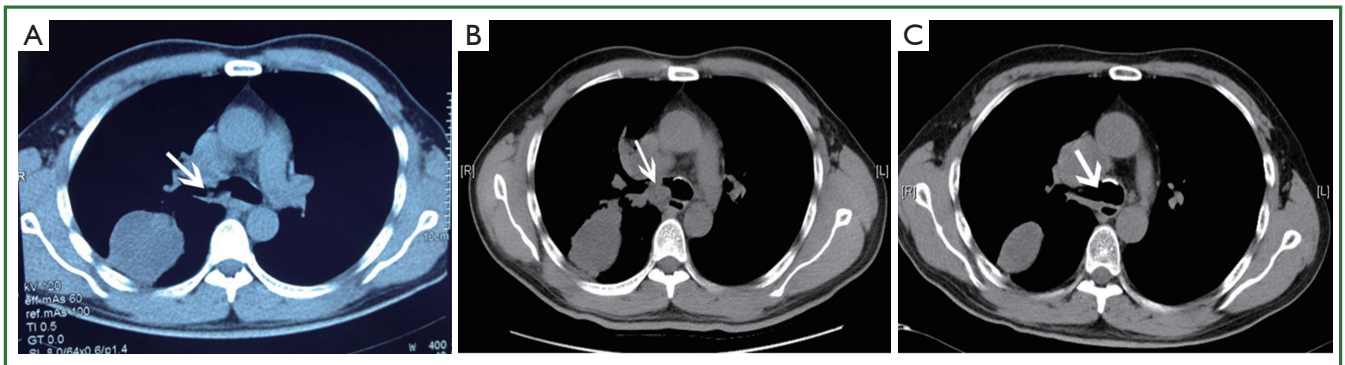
Computerized tomography (CT) scan. A. showing a mass in the right upper lobe and in the right hilar, with evidence of narrowing of the right upper lobe; B. showing a mass with evidence of complete occlusion of the right main bronchus; C. showing the mass was obviously absorbed and the mass of right main bronchus was disappeared.
